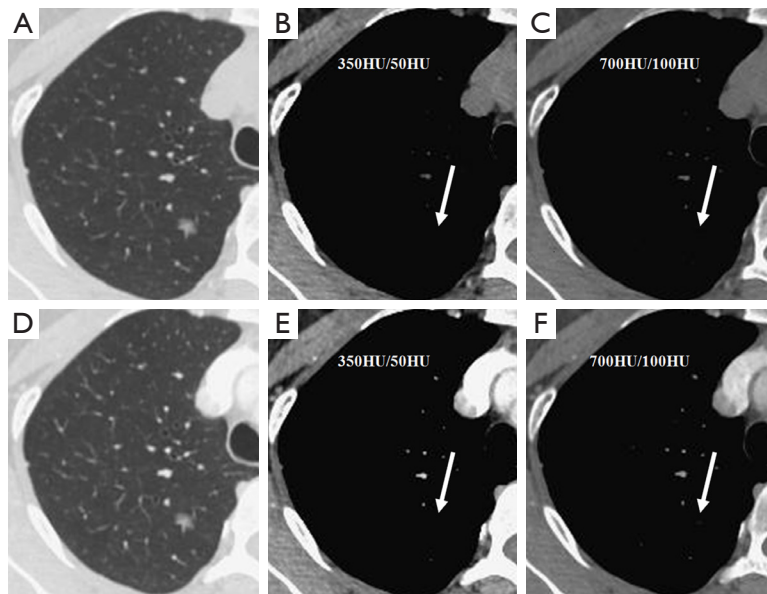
(A-F) A small pGGN (7 mm) in LLL, which was diagnosed as AAH by pathology. No solid portions were detected in plain and contrast CT images in CMW or EMW (arrows show the location of the nodule). No enhancement of this nodule was seen in CT. The mean CT values in (A) unenhanced CT image and (D) enhanced CT image were  $-645$  HU. CT, computed tomography; pGGNs, pure ground glass nodules; CMW, conventional mediastinal window; AAH, atypical adenomatous hyperplasia; EMW, extended mediastinal window; LLL, left lower lobe.
